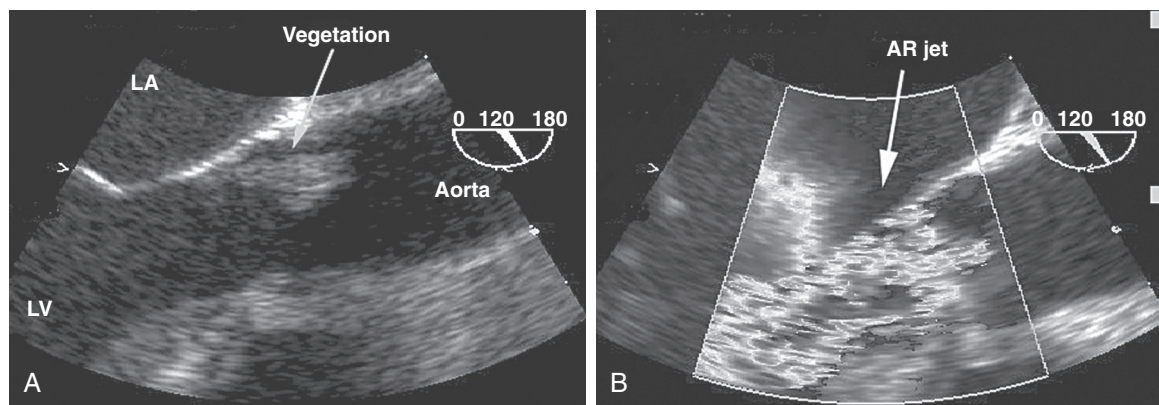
■ Infective endocarditis of the aortic valve. A 55-year-old patient was admitted to the ICU with fever, chills, hypotension, and respiratory distress for which he had to be intubated. He had 4/4 positive blood cultures for *Staphylococcus aureus*. Transthoracic echocardiography was performed initially, but the quality was suboptimal, and no definite conclusion could be reached. Subsequent transesophageal echocardiography revealed a large vegetation on the left aortic coronary cusp as seen in the midesophageal view at 120 degrees (A). Color Doppler examination (B) revealed the presence of associated severe aortic regurgitation (AR). The patient was treated with antibiotics and emergent aortic valvular surgery. LA, left atrium; LV, left ventricle.
